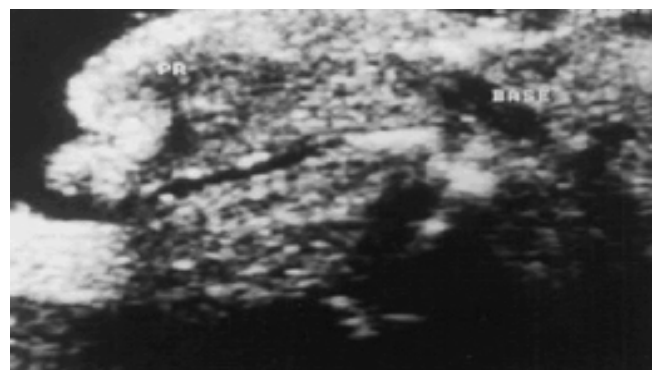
Ultrasonographic autopsy shows the fine details of the anterior median proboscis as an elongated soft tissue structure attached to the area between the two heads.
